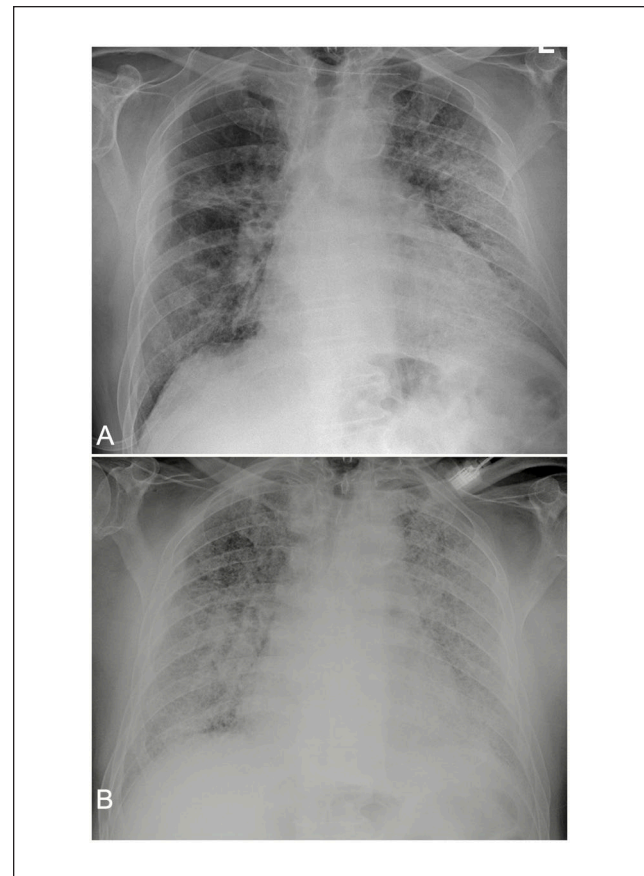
(A) Chest radiograph performed on March 9, 2020 (day of admission): diffuse interstitial-alveolar infiltrates merging into multiple parenchymal thickenings involving the entire left lung and inferior and medium lobe of the right lung. (B) Chest radiograph performed on March 13, 2020 (day 4): progression and worsening of bilateral interstitial pulmonary infiltrates.
